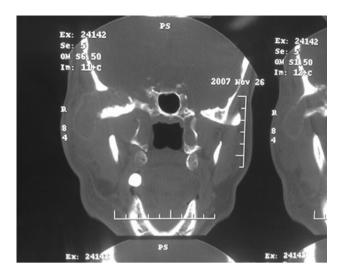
Infratemporal lesion before the first surgery (coronal view of CT scan with IV contrast)
